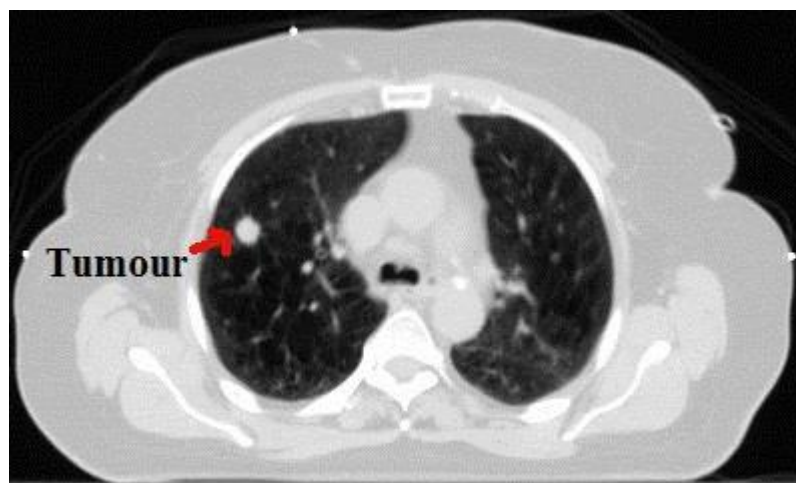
displays an axial slice from a 4-dimensional computed tomography (4D-CT) study of the sample patient. A small lung tumour is apparent in the right lung (left side of the image).
